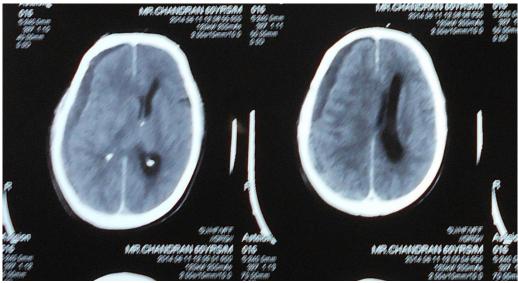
Pre operative CT Scan brain showing Right FrontoTemporo Parietal Acute on Chronic Subdural Hematoma with mass effect
